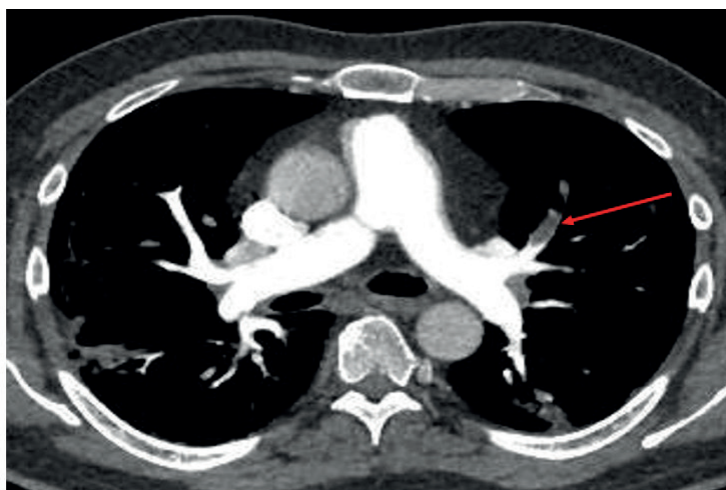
Computed tomography pulmonary angiogram showing filling defect consistent with acute left-sided segmental pulmonary embolus.
